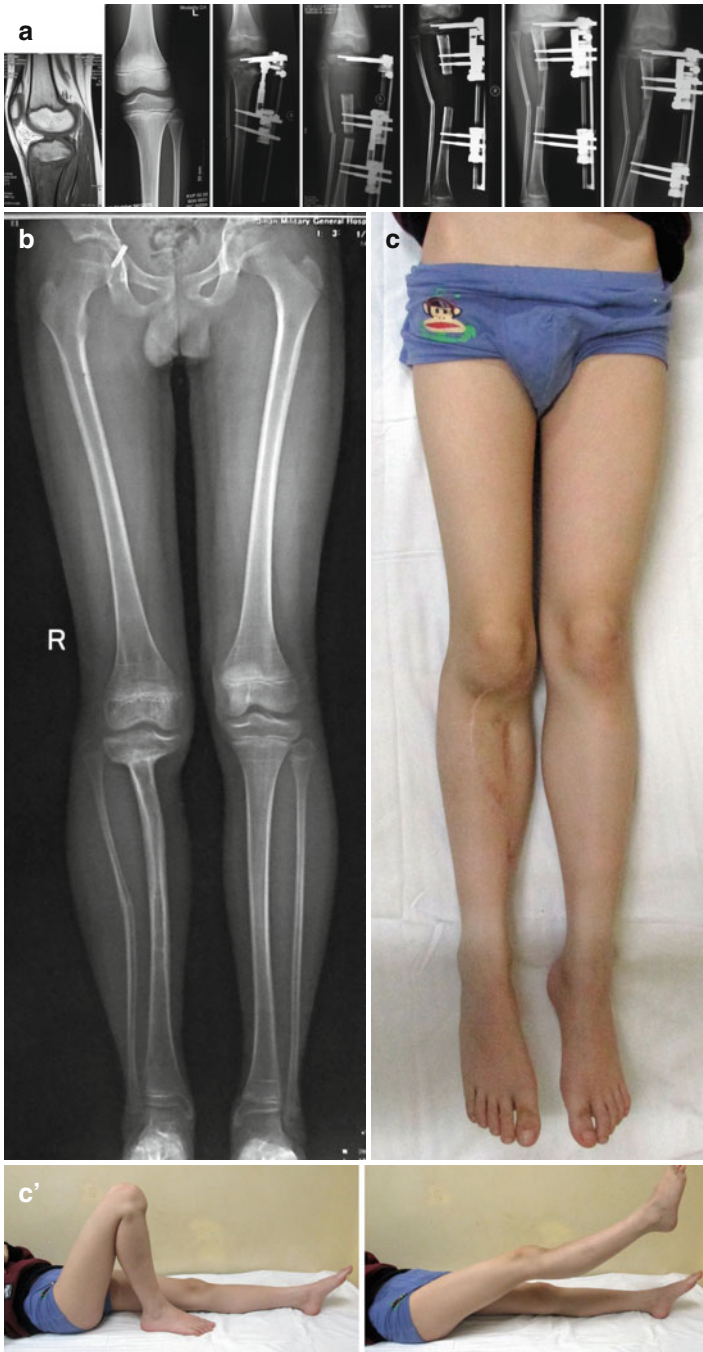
(a) The preoperative MRI showed the tumor to be in contact with the physis. Physseal distraction was achieved, and reconstruction was made through bone transport. After 30 months, X-ray showed full bone union. (b, c) The boy showed limb equivalence with MSTs score of 30 (Endorsed by Pro.XiuChun Yu)
